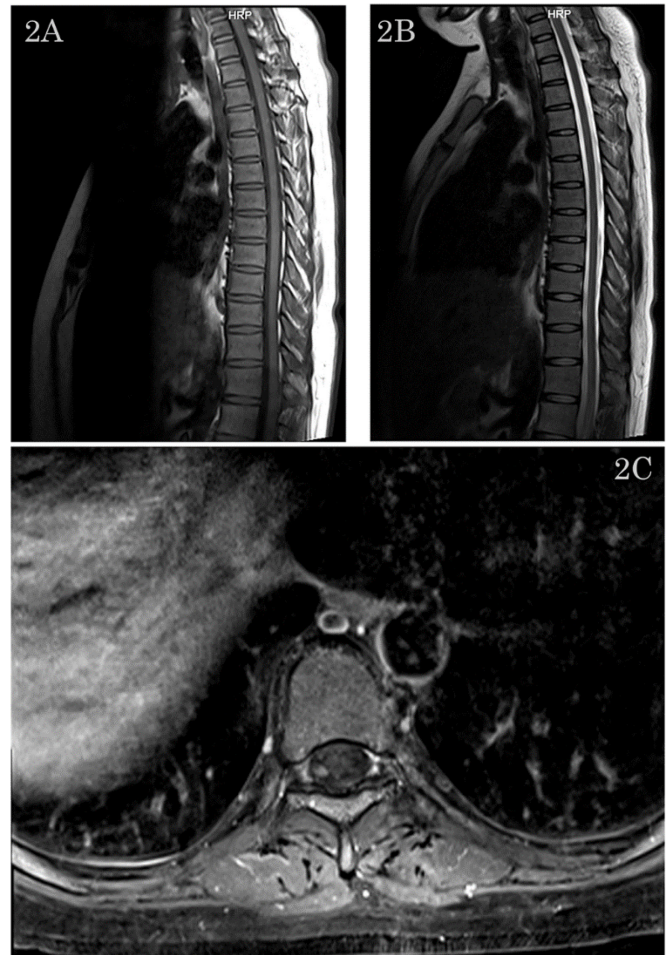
Main findings of neurobrucellosis. Spinal MRI showing increased signal on T1 and T2-weighted sequences extending from T4 to T9 spinal cord segments. A) Sagittal T1-weighted sequence. B) Sagittal T2-weighted sequence. C) Axial T1-weighted sequence.
